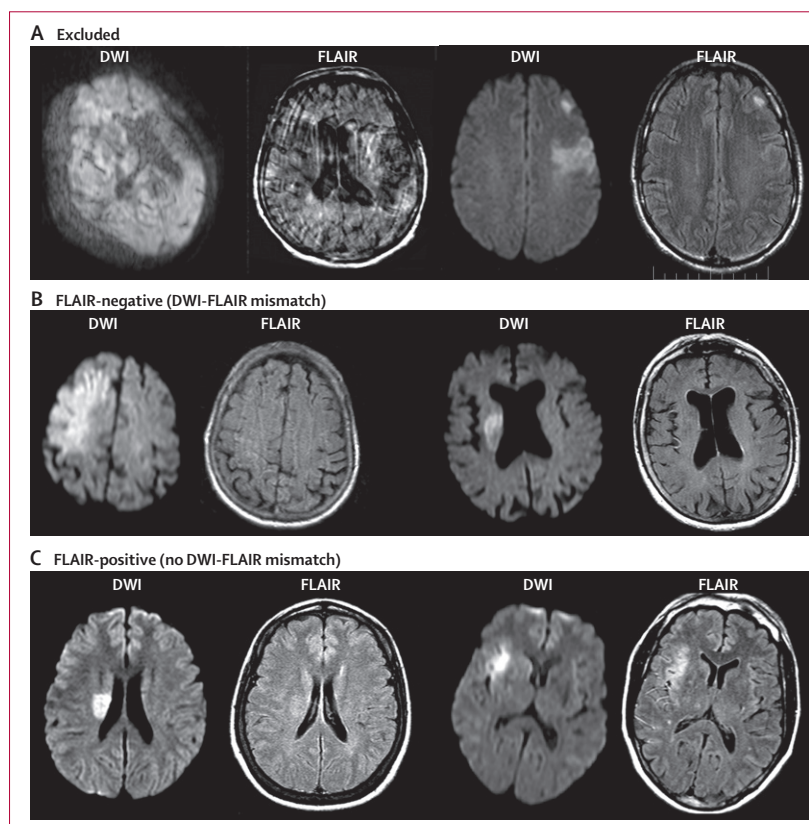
Examples of DWI and FLAIR images
